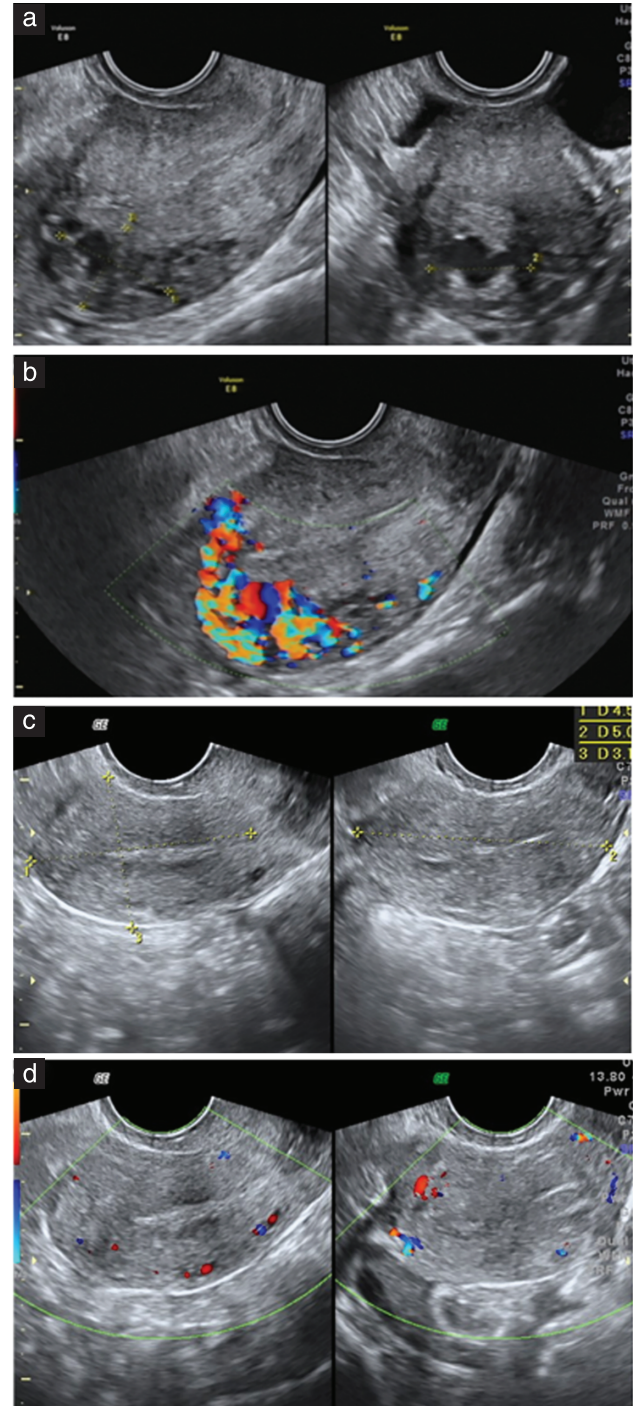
Difference in uterine vascularization between patient with low-risk gestational trophoblastic neoplasia (GTN) and myometrial invasion (a,b) and patient with low-risk GTN without myometrial invasion (c,d). In the case with detectable myometrial invasion, heterogeneous mass is seen on grayscale ultrasound (a) and myometrial vascular-enriched mass on color Doppler (b). In patient without invasion, myometrium appears normal on both grayscale ultrasound (c) and color Doppler (d).
